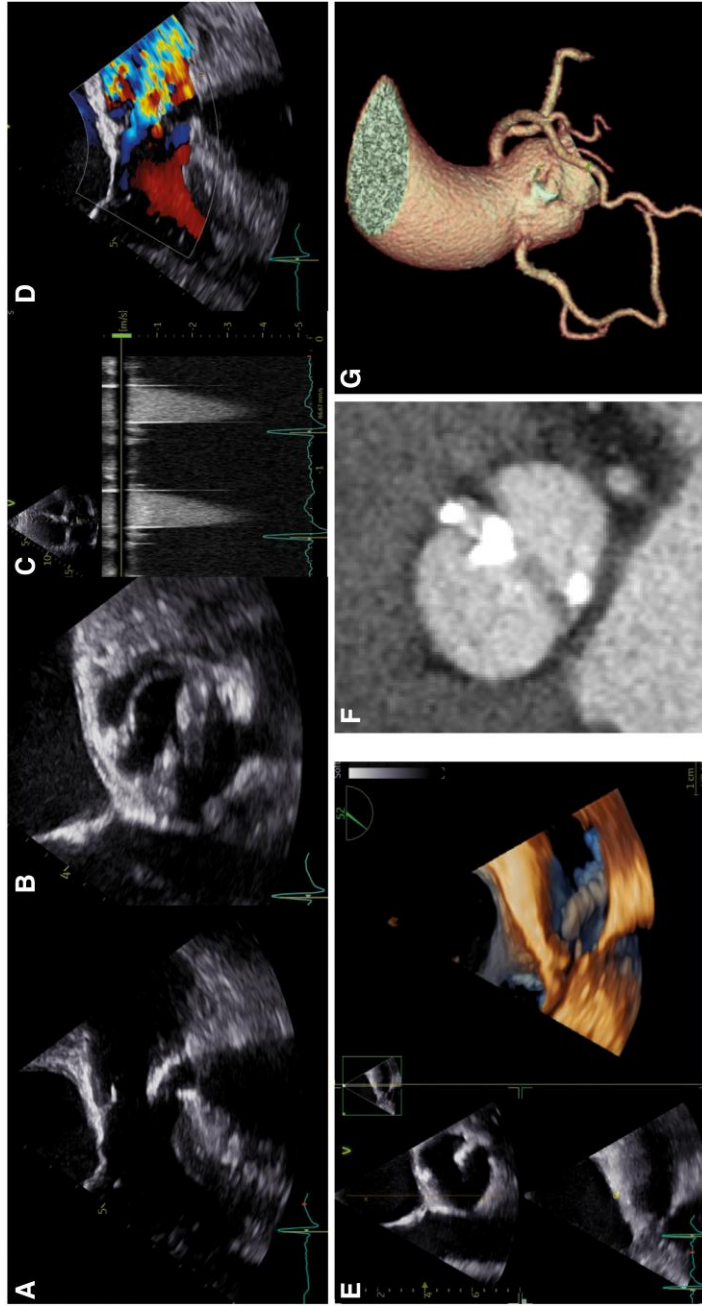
Bicuspid aortic valve (BAV) in a 63-year-old man. Transesophageal echocardiography (2D and 3D; panels A to E) demonstrates a BAV with a two-sinus anatomy, which was confirmed by computed tomography (CT; panels F and G), a feature that is more commonly encountered in men. Interestingly, 3D transesophageal echocardiography identified a long, calcific longitudinal band located just above the aortic valve, within the aortic root. CT imaging further delineated the anatomy of the aortic root and ascending aorta.
